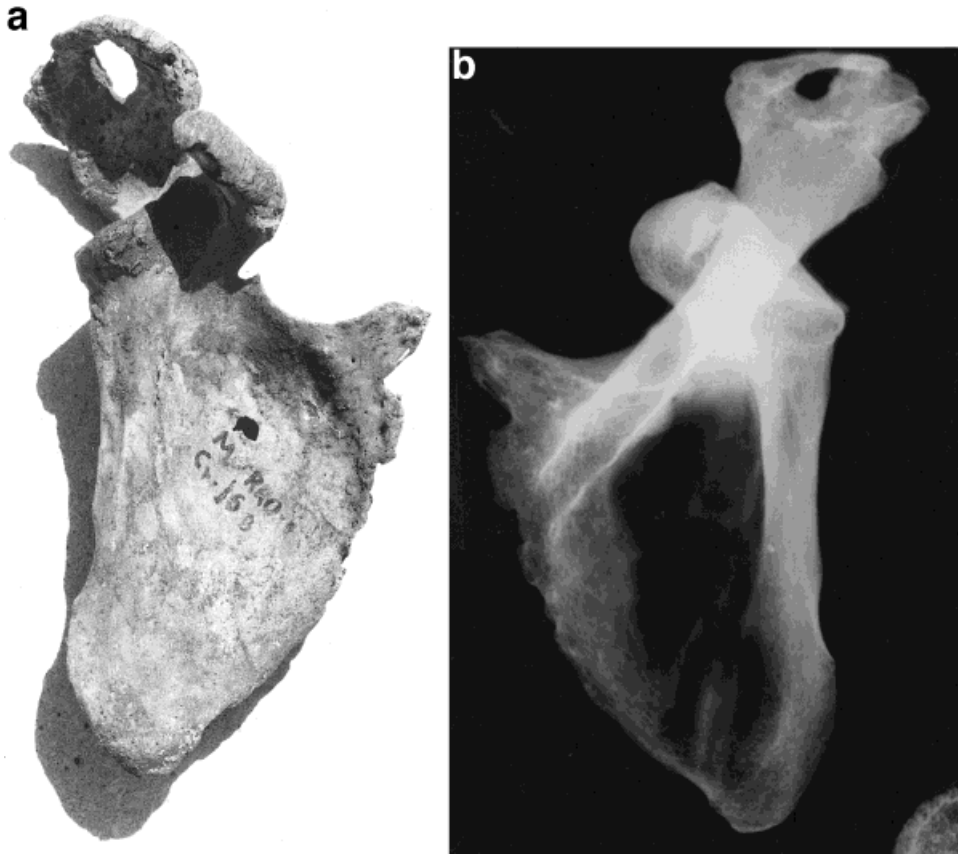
a: Right scapula, with lesion in the acromion, probably the consequence of a compound fracture or injury (case M1/T16B, adult male). b: Radiograph of same case.
